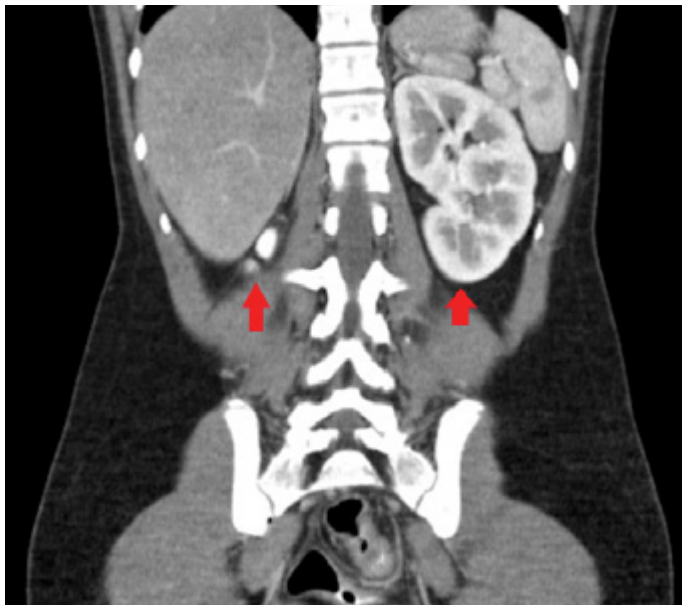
Coronal computed tomographic (CT) scan that shows the left kidney and right renal agenesis.
